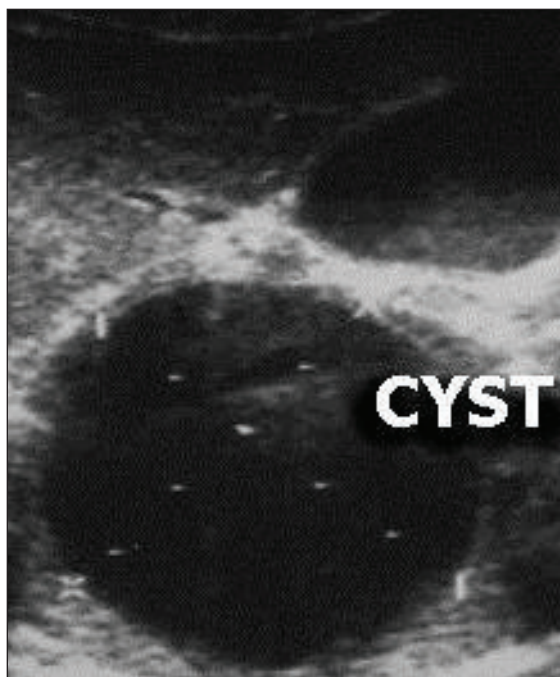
Ultrasonographic demonstration of breast CE.
